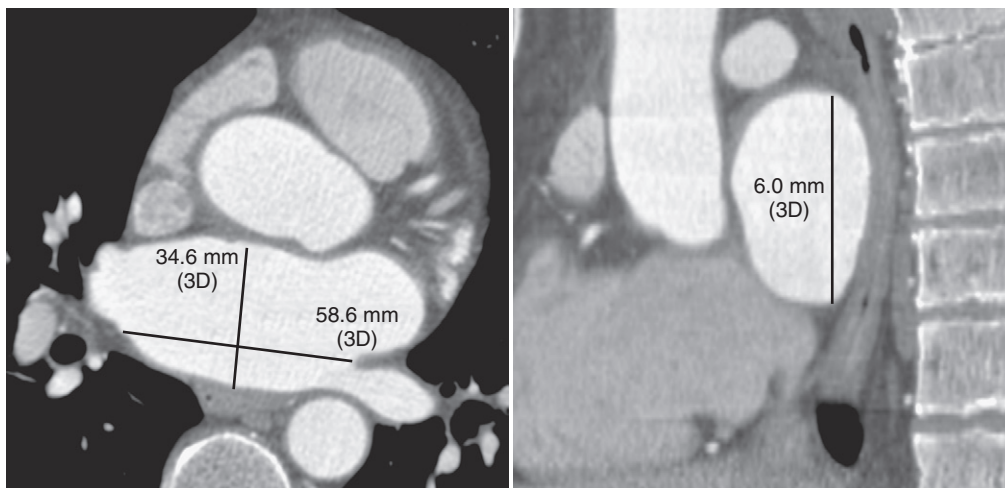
Left atrial measurement. Methods of measuring transverse, lateral, and anteroposterior length of the left atrium are shown. Localization of points over the three-dimensional (3D) computed tomography model made to create a localization line over the axial datasets is depicted. The image has been rotated to visualize all the highlighted points simultaneously.
